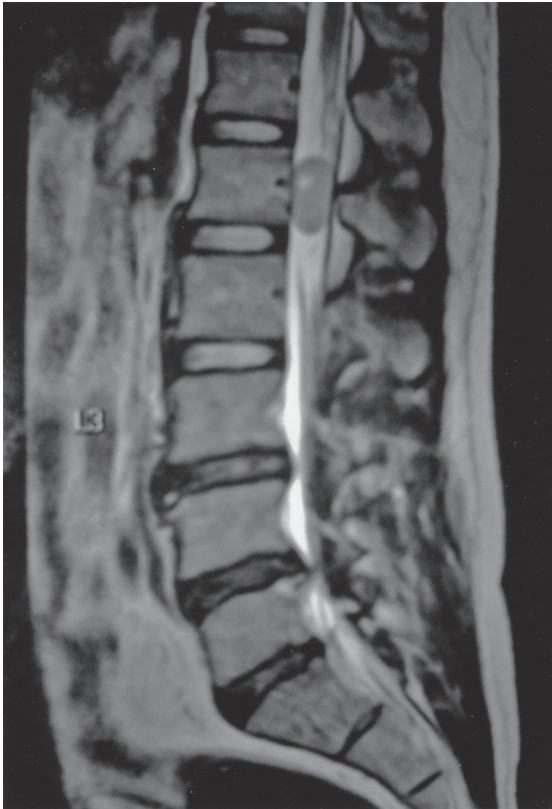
Preoperative sagittal T2-weighted lumbosacral MR imaging shows tumour at L1 vertebral level.
